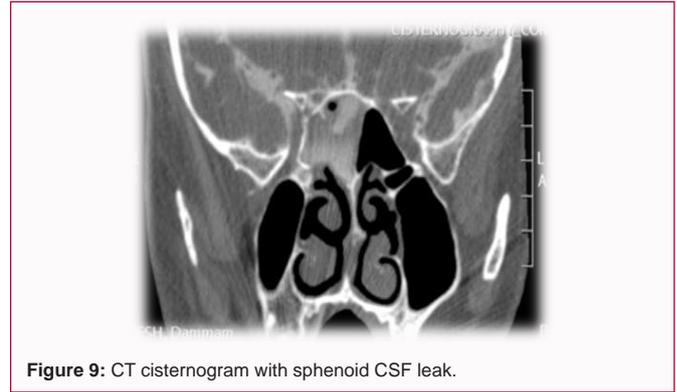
CT cisternogram with sphenoid CSF leak.
